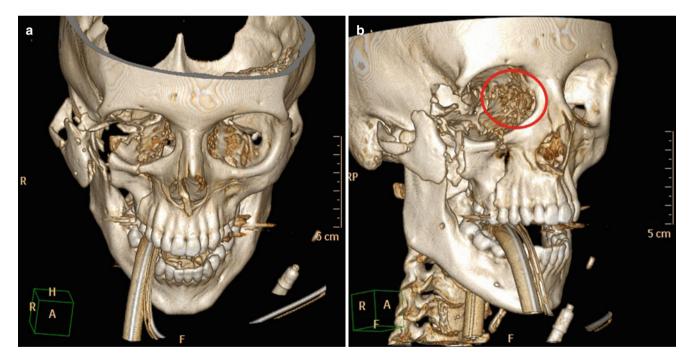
Overview of injuries sustained (a, b). Although these scans clearly show the extensive fractures to the zygoma, they do not detail the injuries to the NOE region. The medial orbital wall appears to be fractured but on 3D scans this is an unreliable finding. *Red circle* indicates the area of disruption of the medial canthus. In this case the detached tendon does not feature on the 3D CT image
